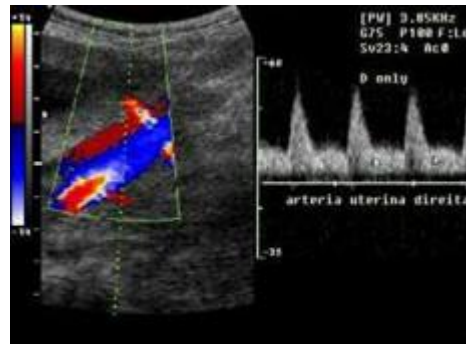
Imagem representativa da forma da onda dopplerfluxométrica da artéria uterina de uma gestante normal.
